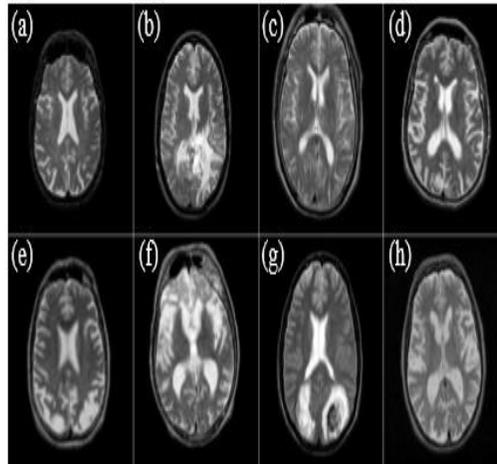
Brain MRI Images
